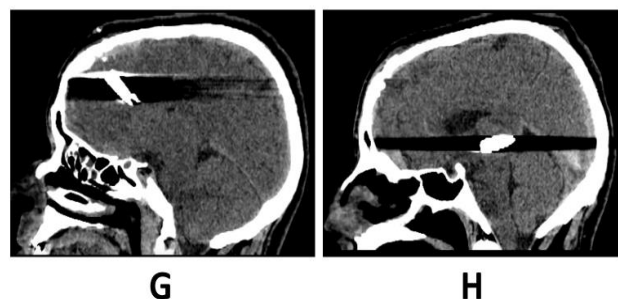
Head CT in sagittal view, G: before bullet migration, H: after bullet migration.
